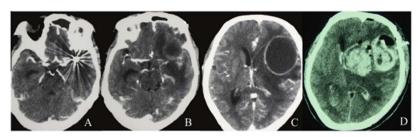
(A-C) Axial contrast-enhanced CT scan showing the coils and brain abscess adjacent to the aneurysm. (D) Axial CT scan showing the ruptured aneurysm following the external drainage procedure.
